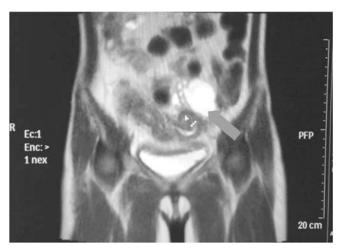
MRI: Multiloculated and multiseptaed structure in the left adnexae probably the left ovary (Arrow).
